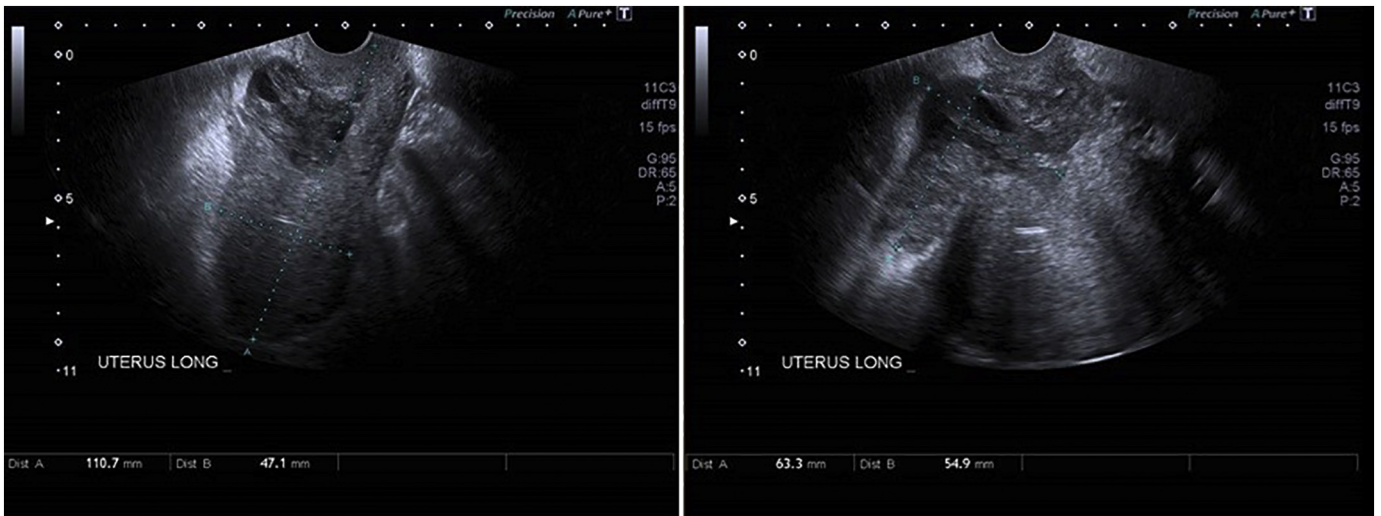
Transvaginal ultrasound scan (TVS) of axial uterus showing a 6x6cm heterogeneous avascular focus extending from the endometrium through the location of the previous CS scar and along the outside anterior right surface of the uterus.
